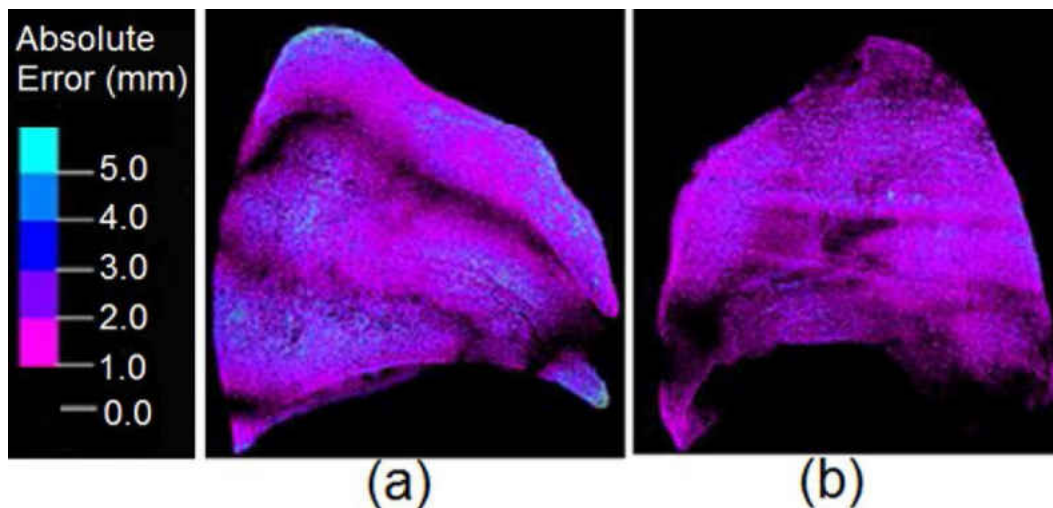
Differences in the displacement observed between the optimal lung deformation and the deformation observed in the 4D-CT DIR shown for (a) left and (b) right lungs
